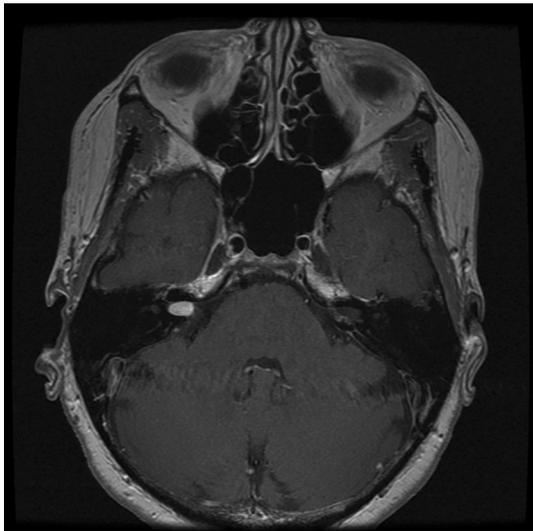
Axial MRI with contrast showing right internal auditory canal mass (10 mm). There is no extension to the cerebellopontine angle
